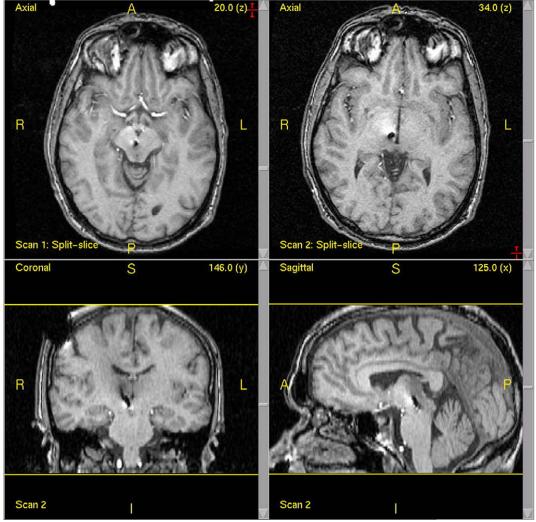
Post-operative T1-weighted MRI (upper, axial; lower left, coronal; lower right, sagittal views) showing the deep brain stimulation electrode location in a patient treated for cluster headache in Oxford, UK.
